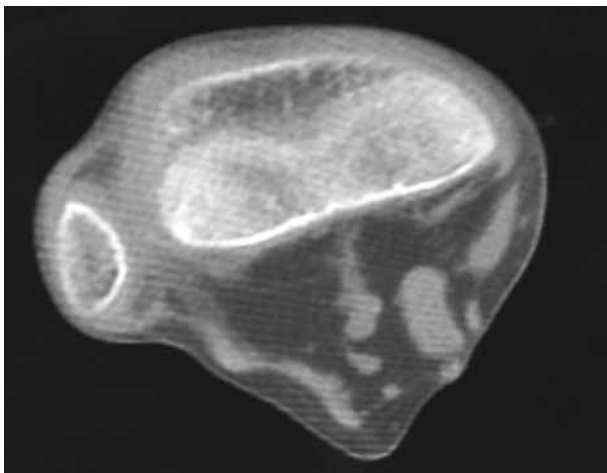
CT-scan of the right knee in the patient with severe learning difficulties confirming lateral dislocation of the patella.
